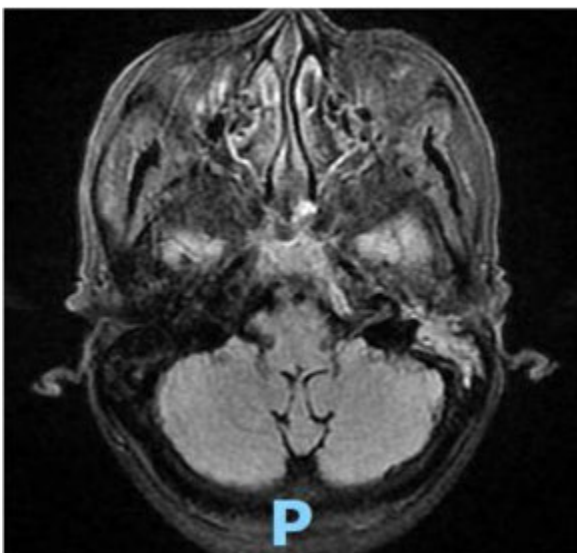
MRI with and without contrast showing abscess.
